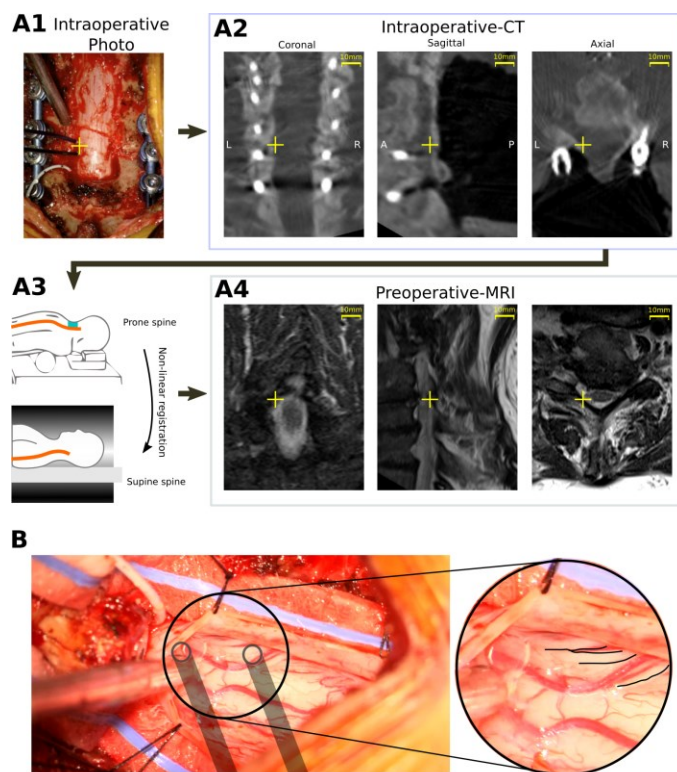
Validation of stimulation location relative to dorsal root entry zones. (A) Transformation of electrode stimulation site from physical location to MRI space. (A1) A photograph was used to identify the position of electrodes relative to instrumentation. (A2) This location was translated to a CT scan used to confirm implant location (yellow crosshatch). (A3) CT and MRI images were co-registered by performing a non-linear segmental registration (Brainlab AG) to account for differences in spinal alignment found in prone (operative) and supine (preoperative) positions. (A4) Electrode position in MRI near targeted C7 root verified location. (B) Exposed subdural region with overlaid location of stimulated location and dorsal roots highlighted in inset. Placement based on anatomical landmark identification was confirmed to position the electrodes over the dorsal root entry zones.
